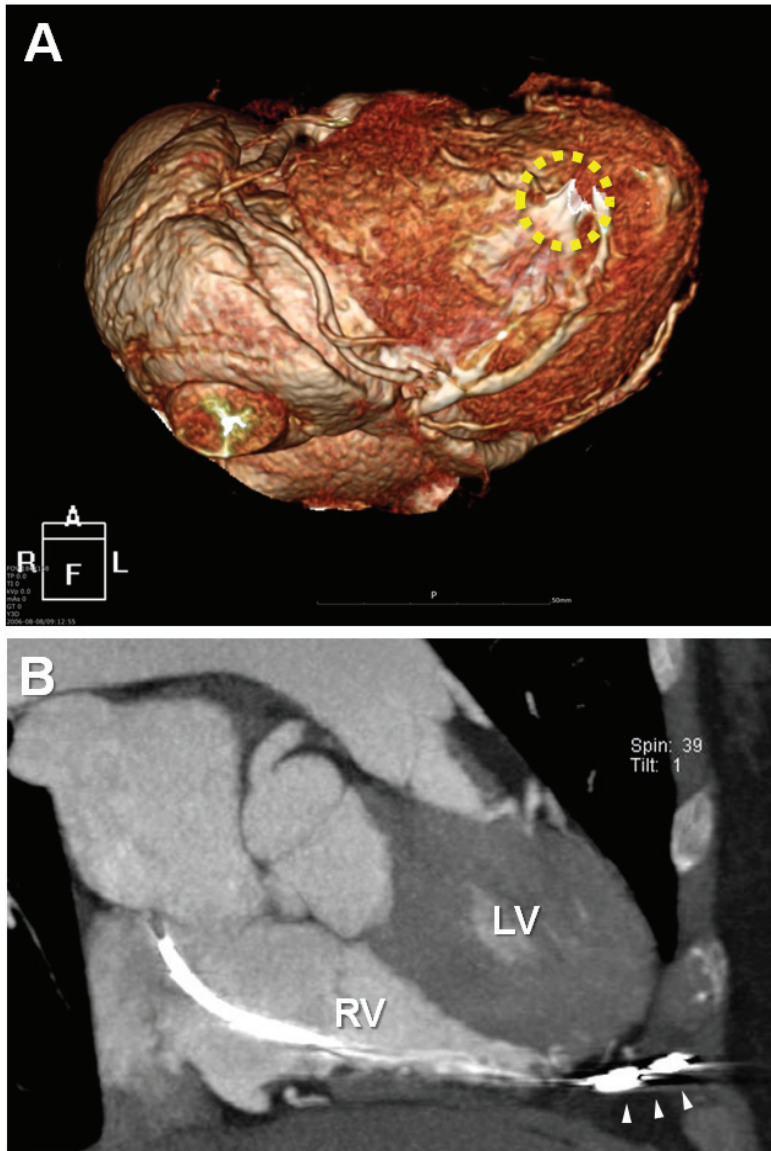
Multi-detector CT scan images. A, Distal portion of the lead (dotted circle) is observed in the 3D reconstruction image. B, Arrowheads indicate the pacemaker lead penetrating RV apical myocardium and extending to anterior chest wall. LV, left ventricle; RV, right ventricle.
